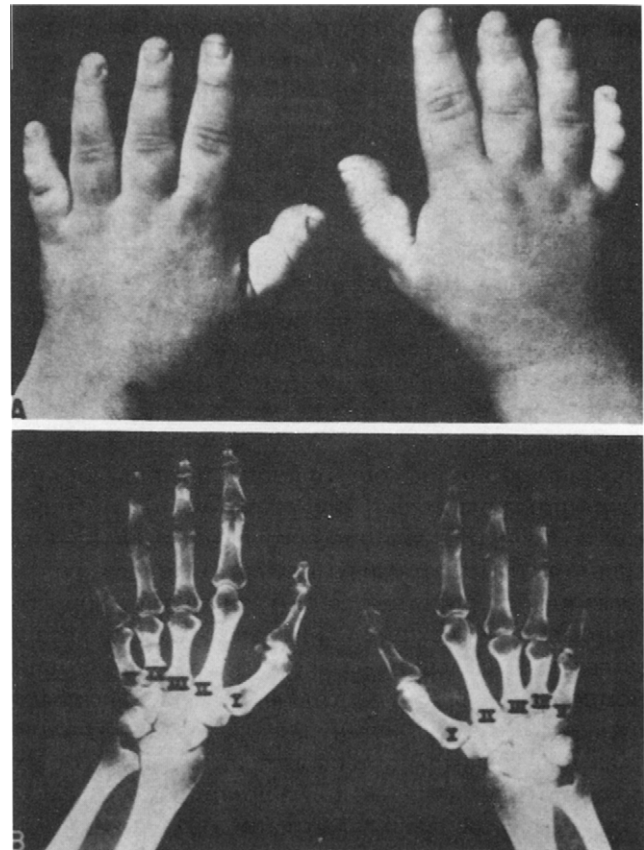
Photograph and X-ray film of hands of a patient with pseudohypoparathyroidism. Note that all digits, except the thumbs and index fingers, are shorter than normal. The shortness results mainly from short metacarpals. Modified from Albright, F., and Reifenstein, E. C. (1948). "The Parathyroid Glands and Metabolic Bone Disease." Williams & Wilkins, Baltimore.
